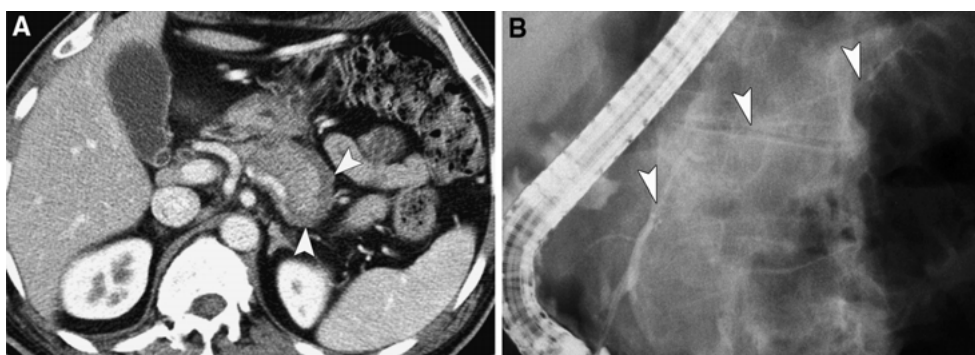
AIP in a 46-year-old man that presenting as jaundice for 8 months. A Contrast-enhanced transverse CT scan shows the low attenuation rim (*arrowheads*) in the pancreas tail. B ERCP image shows multiple narrowings of the main pancreatic duct (*arrowheads*) involving all segments of the pancreas.
